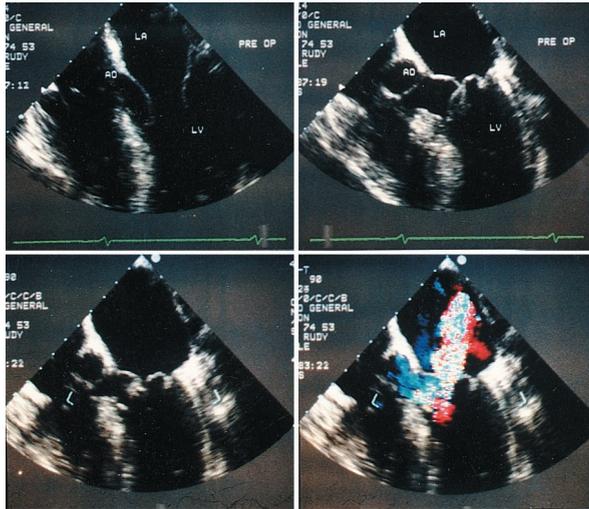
Intraoperative transesophageal echocardiography images demonstrating systolic anterior motion of the anterior mitral valve leaflet (upper right panel) and an interleaflet gap (lower left panel) through which a jet of mitral regurgitation (lower right panel) is centrally directed into the left atrium. The central jet is due to the combination of LVOT obstruction and posterior mitral valve leaflet prolapse. Ao = aorta; LA = left atrium; LV = left ventricle.
